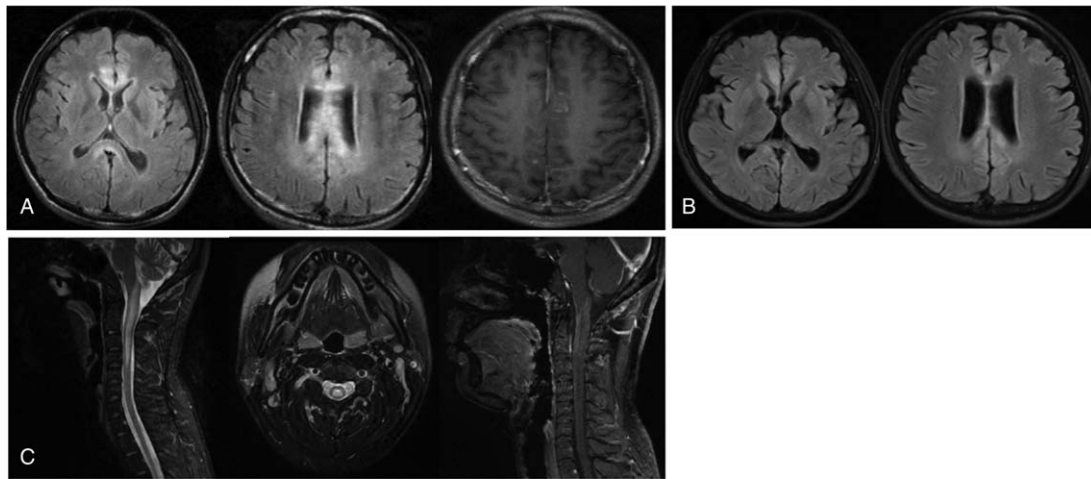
Brain MRI (sagittal T2 FLAIR images) showed high signal in the white matter and peri-ventricular with contrast-enhancing lesions at T1 (A). Brain MRI showed a high signal reduced after immunotherapy (B). MRI of the cervical cord showed T2 hyperintensities from the dorsal medulla to C4, including contrast-enhancing lesions (C).
